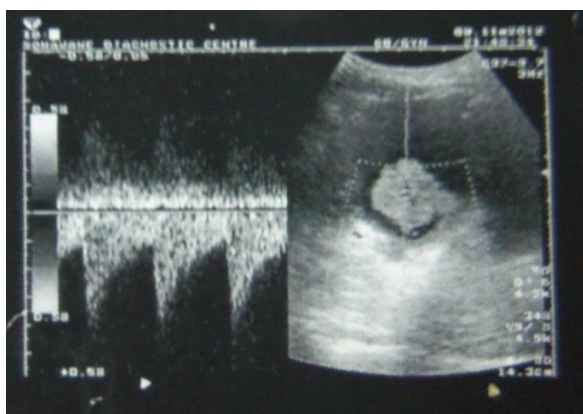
An abdominal ultrasound showed thickened urinary bladder wall and a 42x34mm mixed echogenic mass posterolaterally with vascularity.
